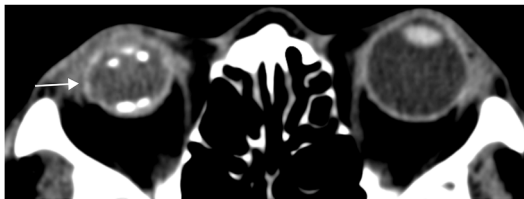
Axial CT orbits demonstrating a shrunken and calcified right eye consistent with phthisis bulbi (white arrow).
